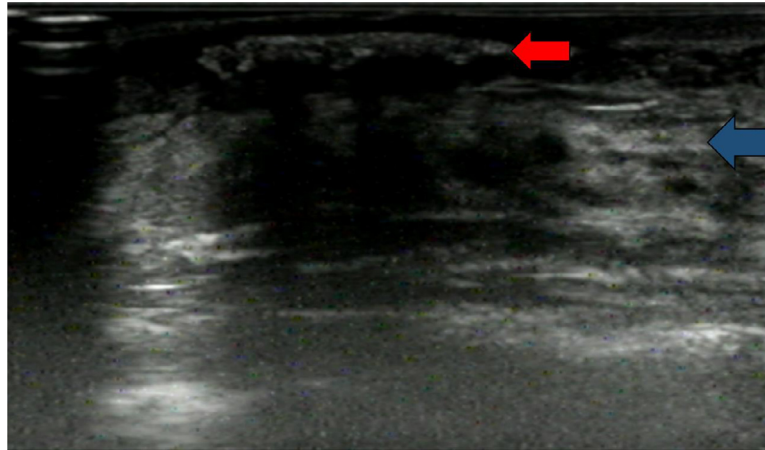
Right breast ultrasound showed hyperechoic structures (red arrow) with posterior acoustic shadowing in the subcutaneous tissue and ill-defined hyperechoic breast tissue (blue arrow) representing infiltrated and inflamed fat lobules.
